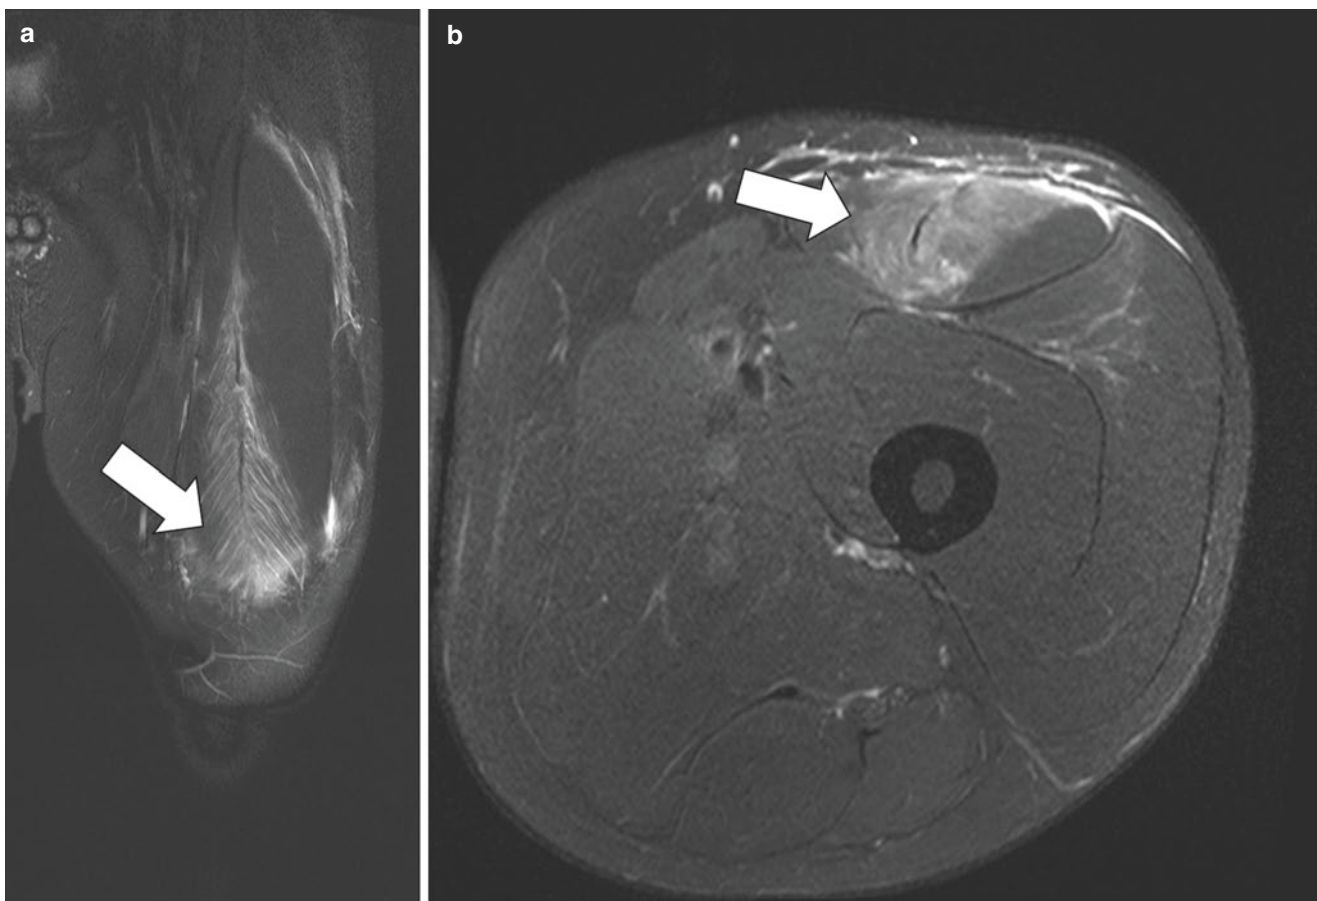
Coronal (a) and axial (b) fat-saturated STIR MR images of the left thigh demonstrate feathered edema along the myotendinous junction of the rectus femoris muscle. No fiber disruption is identified in keeping with a grade 1 muscle injury
